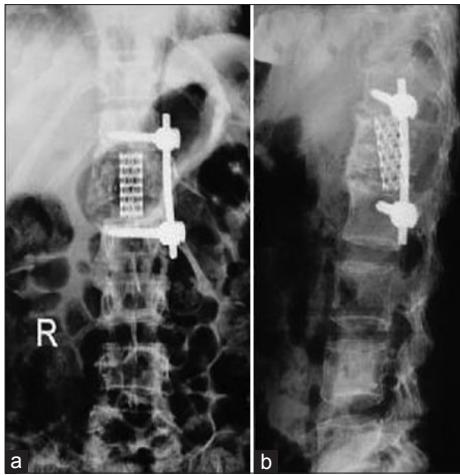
Anteroposterior and lateral postoperative X-rays (a and b) showing adequate excision of the vertebral bodies and instrumentation
